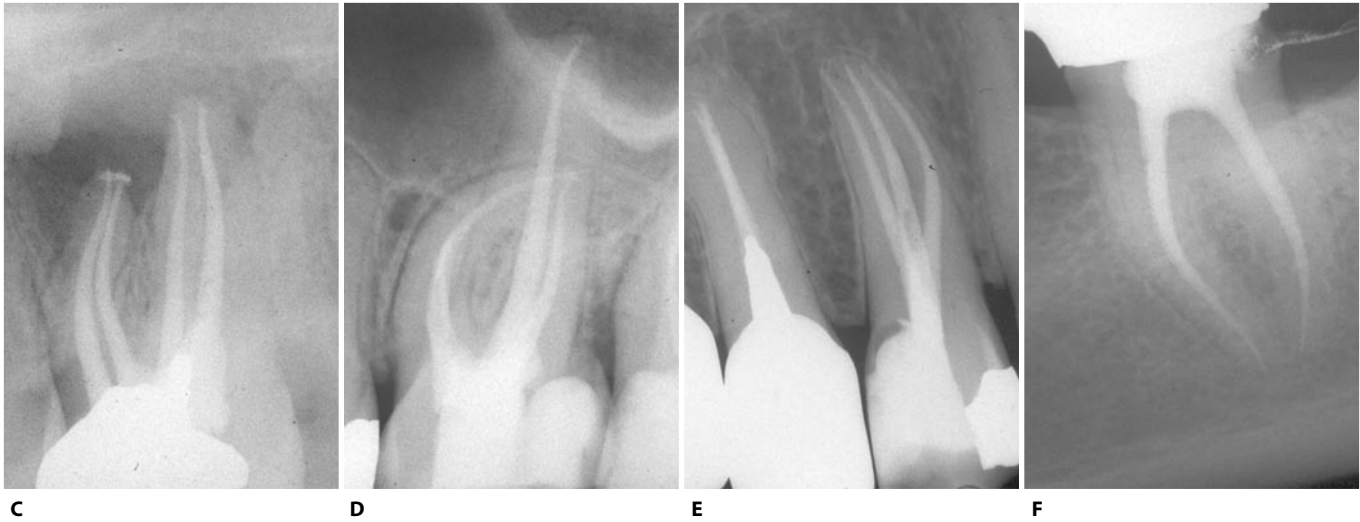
A-I. Post-operative radiographs of teeth shaped using the GT Rotary files (Courtesy of Dr. A. Castellucci).
